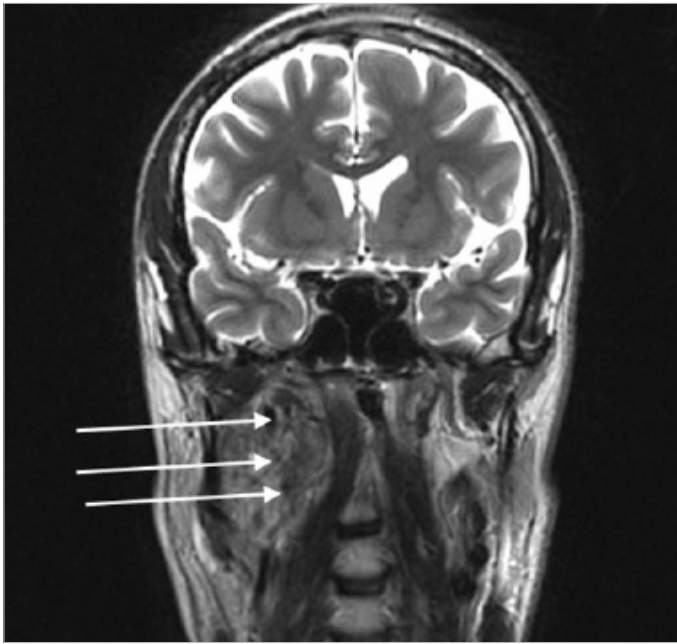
MRI scan of a tumor of the neck and skull base on the right side in frontal projection, presenting with radiological features of increased vascularization.
